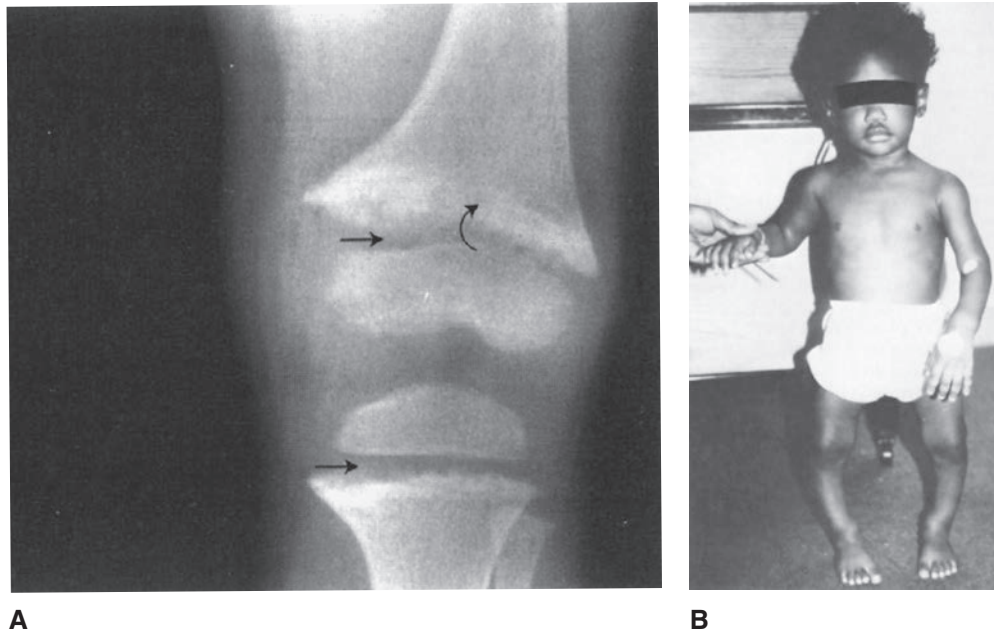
Rickets. A. Radiograph of the left knee joint showing widening of the growth regions of the bones (*arrows*). B. Young child showing rickets.
